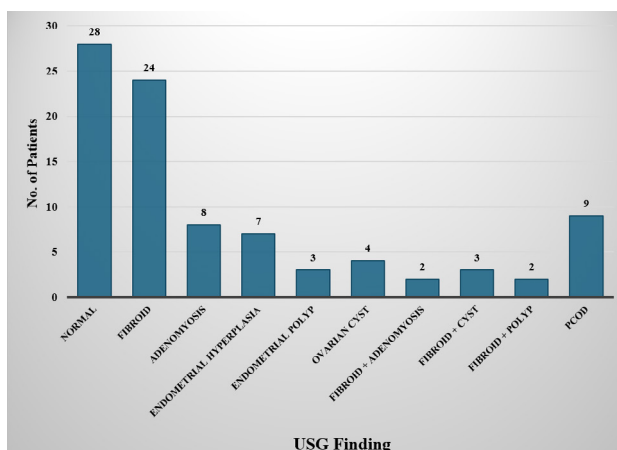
Distribution of patients according to Ultrasonographic (USG) Findings.
